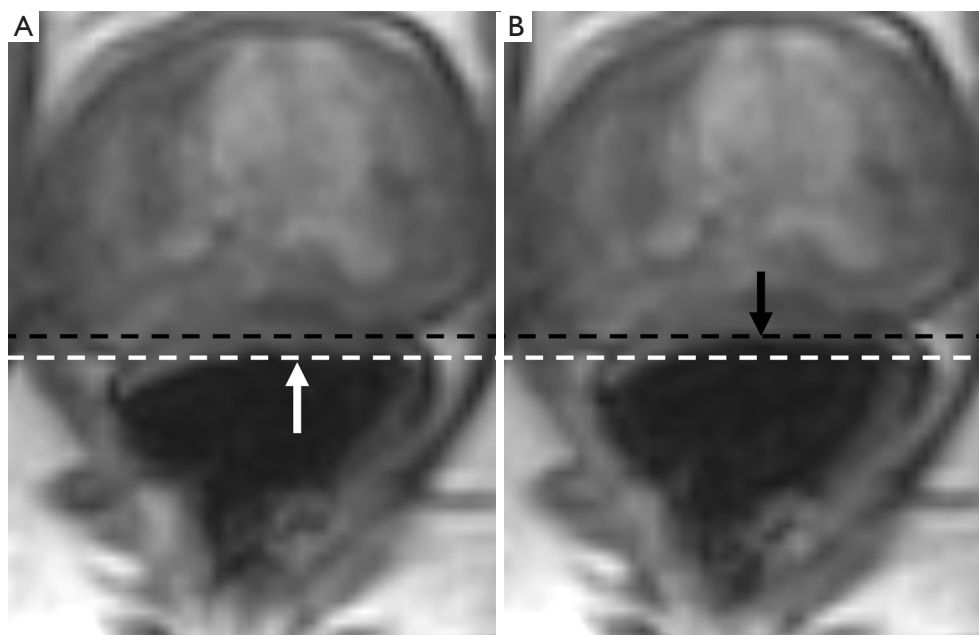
Anterior rectal wall motion evaluated on dynamic contrast enhancement MRI shows posterior (A) and anterior (B) excursions. Dashed lines and arrows indicate the outline of the posterior (A) and anterior (B) excursions. MRI, magnetic resonance imaging.
